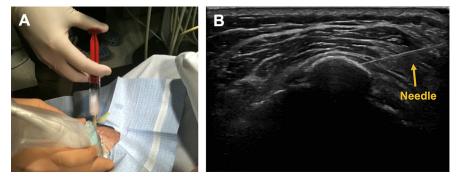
(A) Ultrasound-guided barbotage of calcific tendinitis in the supraspinatus. (B) Ultrasound image demonstrating insertion of a needle directly into a calcific deposit, followed by lavage (usually with normal saline) to dissolve the deposit.
